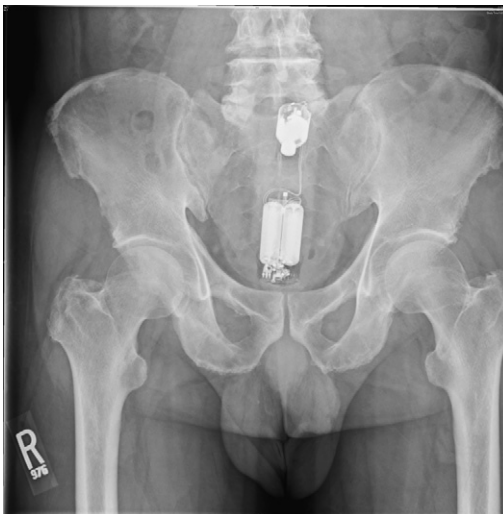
Rectal vibrator on abdominal plain film. (Courtesy of Joel Goldberg, MD, Boston, MA.)
